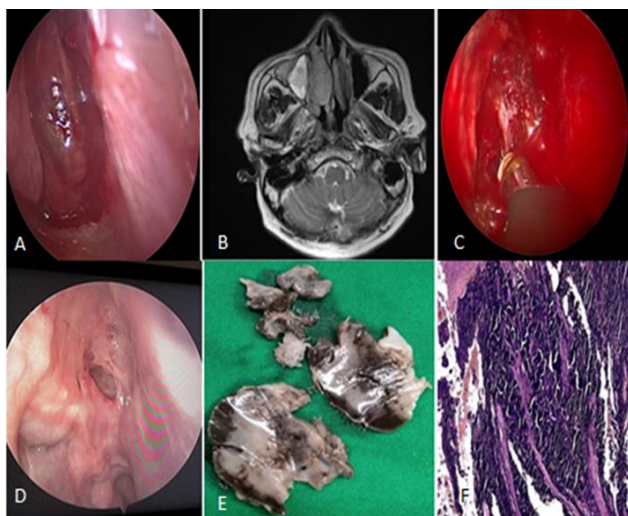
(A-F): Image showed DNE image, axial CT PNS, intra operative image, 2 months postoperative DNE image, gross section and HPE
